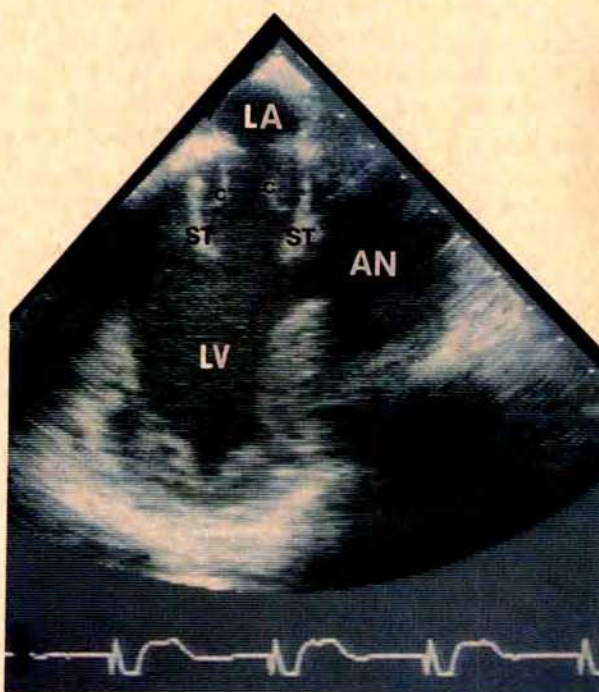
Transesophageal 2-dimensional echocardiogram of patient with normal functioning bioprosthetic mitral valve. Note thin cusp (c) in its open position. This patient, incidentally, also had submitral left ventricular aneurysm (AN). LA = left atrium; LV = left ventricle; ST = valve stents.
